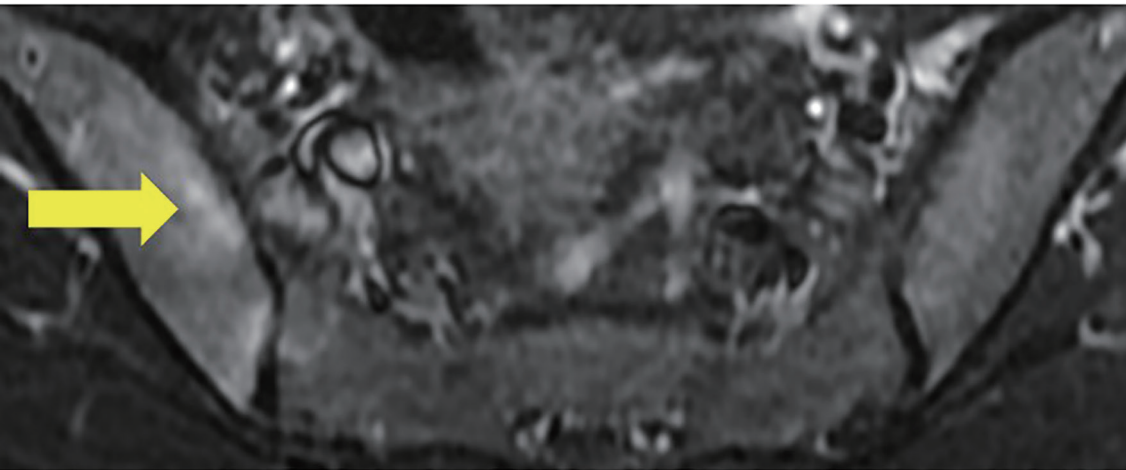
Figure Axial STIR pelvic magnetic resonance imaging demonstrating high intensity signal (arrow) in the sacroiliac joint. (A) Before GMA apheresis. (B) After GMA apheresis
